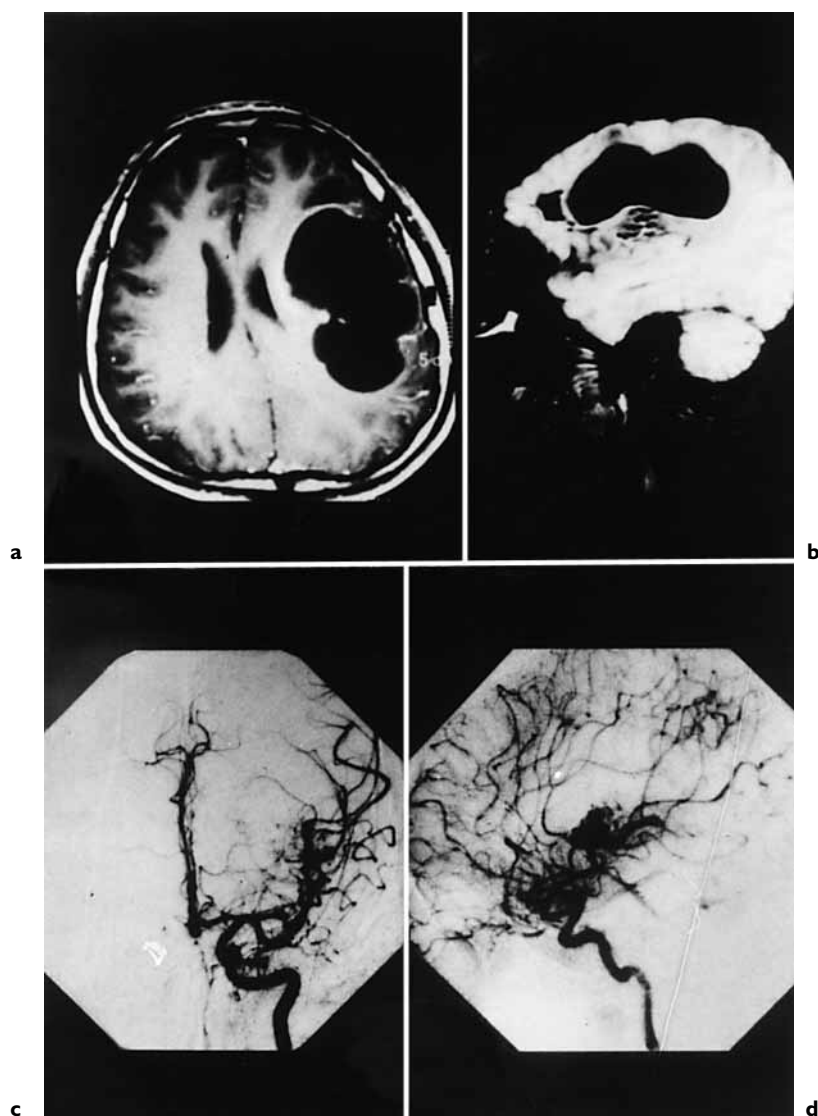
a, b Sequential T1-weighted MR images obtained 11 months after radiosurgery showing an enlarging hypointense cyst. c, d Angiogram obtained 11 months after radiosurgery showing partial obliteration of the AVM nidus.
